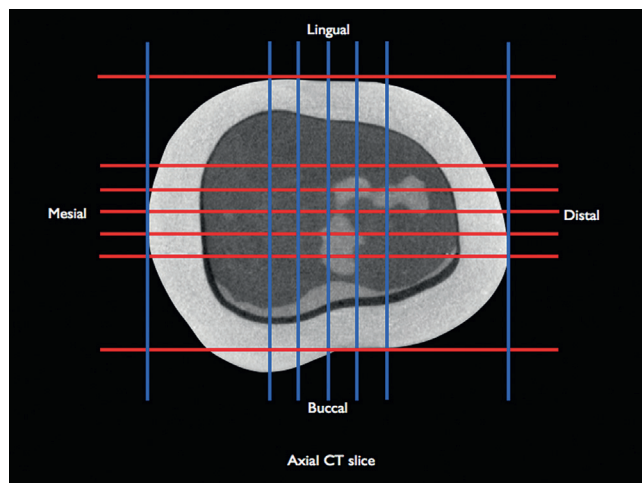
Central third of horizontal cut of microcomputed tomography scan image with 5 equidistant vertical cuts in buccolingual direction and 5 equidistant vertical cuts in mesiodistal direction.
